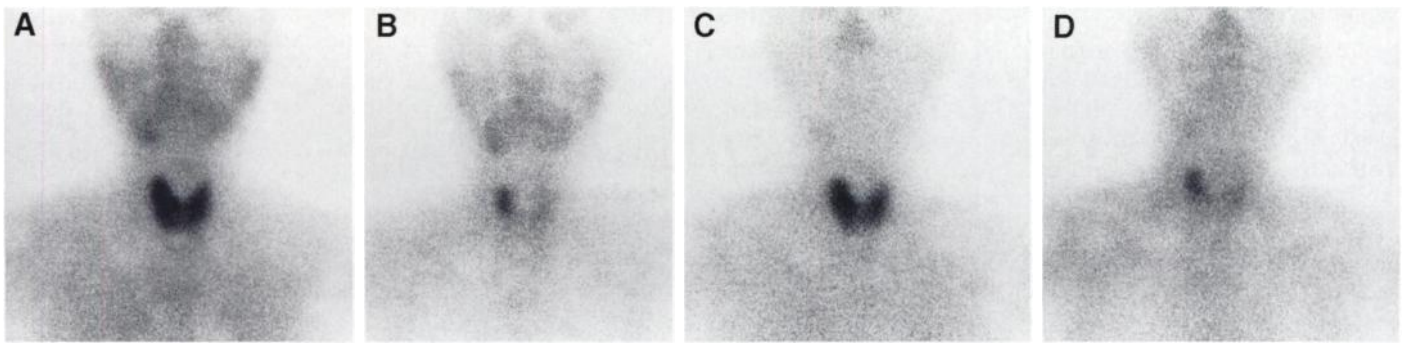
(A) Early ^{99m}Tc -MIBI image in a patient with papillary carcinoma in the right lobe of the thyroid. Accumulation in the tumor was nearly identical to normal thyroid tissue. (B) Delayed ^{99m}Tc -MIBI image in the same patient showing a high accumulation in the tumor but low accumulation in normal thyroid tissue. (C) Early ^{201}Tl image in the same patient. Accumulation in the tumor was nearly equal to that in the normal thyroid tissue. (D) Delayed ^{201}Tl image in the same patient. The tumor had high accumulation, and the normal thyroid tissue had low accumulation. Findings were nearly identical for both ^{99m}Tc -MIBI and ^{201}Tl scintigraphy, but ^{99m}Tc -MIBI images were slightly clearer.
